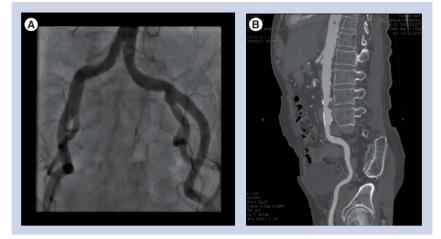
Evaluation of the femoroiliac axes. (A) Conventional angiography, showing the general anatomy of the arterial axes and allowing quantitative assessment of the minimal luminal diameters between the origin of the common iliac arteries and the access site on the common femoral arteries. (B) Multislice computed tomography (sagital view) to detect eccentric calcifications.
